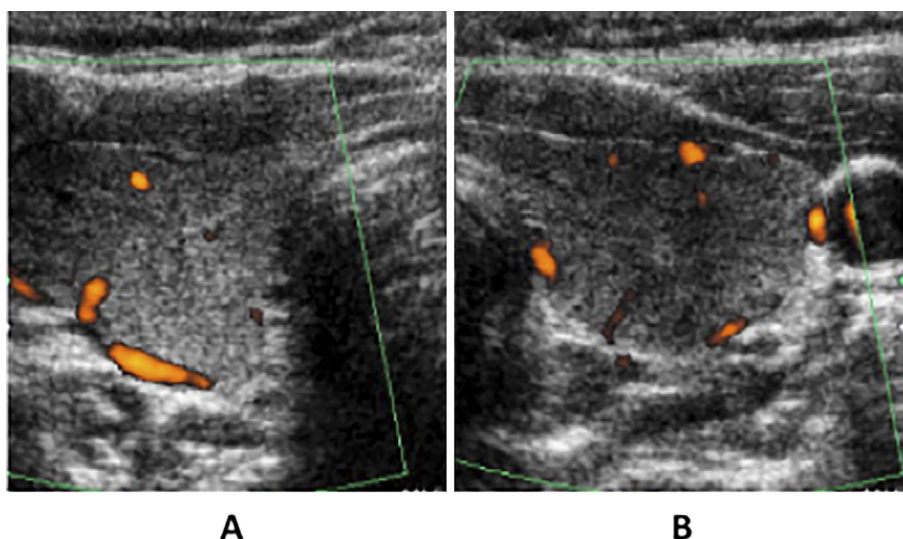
Ultrasonography showing the low blood flow in the thyroid. A: Right lobe, B: Left lobe.
